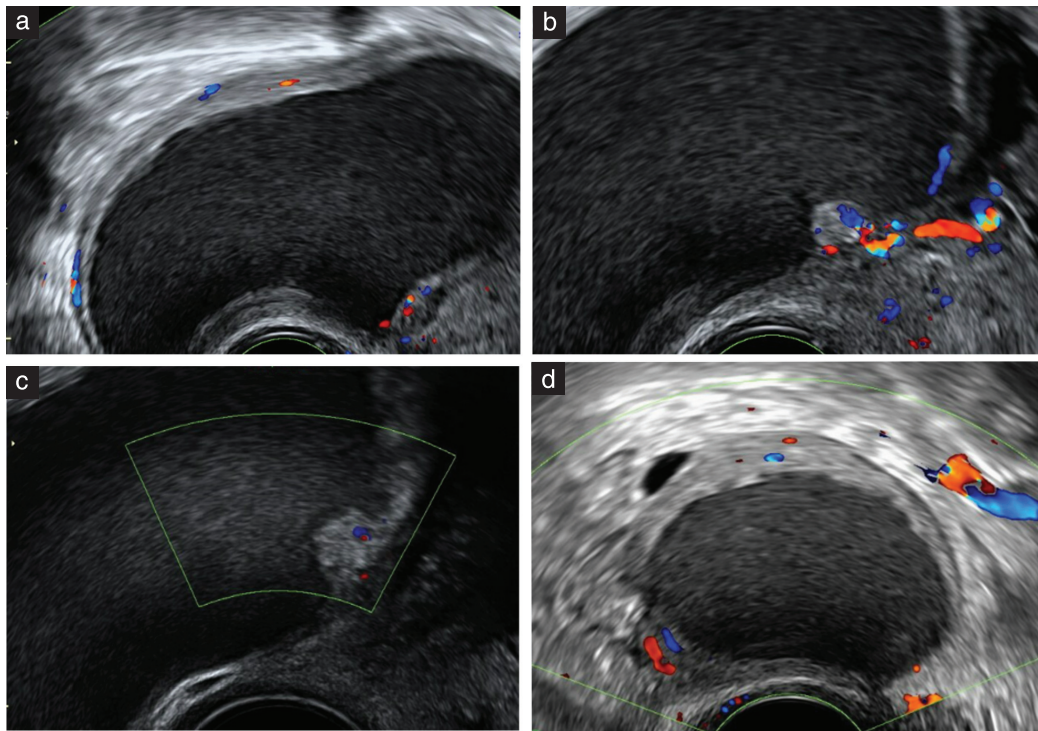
Transvaginal color Doppler images showing transverse view of left ovary in 42-year-old primigravida presenting with light vaginal bleeding. (a,b) Examination at presentation at 9 + 6 weeks' gestation revealed unilocular thick-walled cyst containing hypoechoic fluid, measuring 72 mm in mean diameter (a) and containing prominent solid papillary projection that demonstrated high vascularity (b), consistent with decidualized endometrioma. (c) At 12 weeks' gestation, cyst was reduced in size, measuring 70 mm in mean diameter, and papillary projection was less prominent with weaker color Doppler signal. (d) At postnatal follow-up, cyst measured 37 mm in mean diameter, appearance was typical of ovarian endometrioma and all features of decidualization had resolved.
